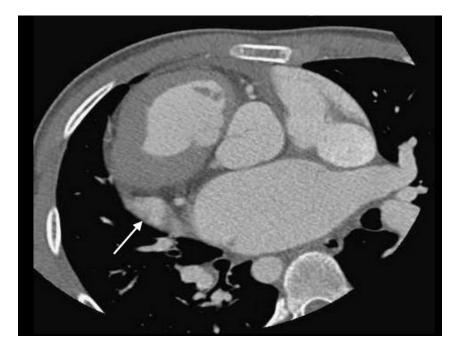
CT axial image shows the morphological left appendage (white arrrow), which is tubular, narrow and finger-like shape, on the right side. Situs inversus is considered and is designated as $\{I, _, _\}$
